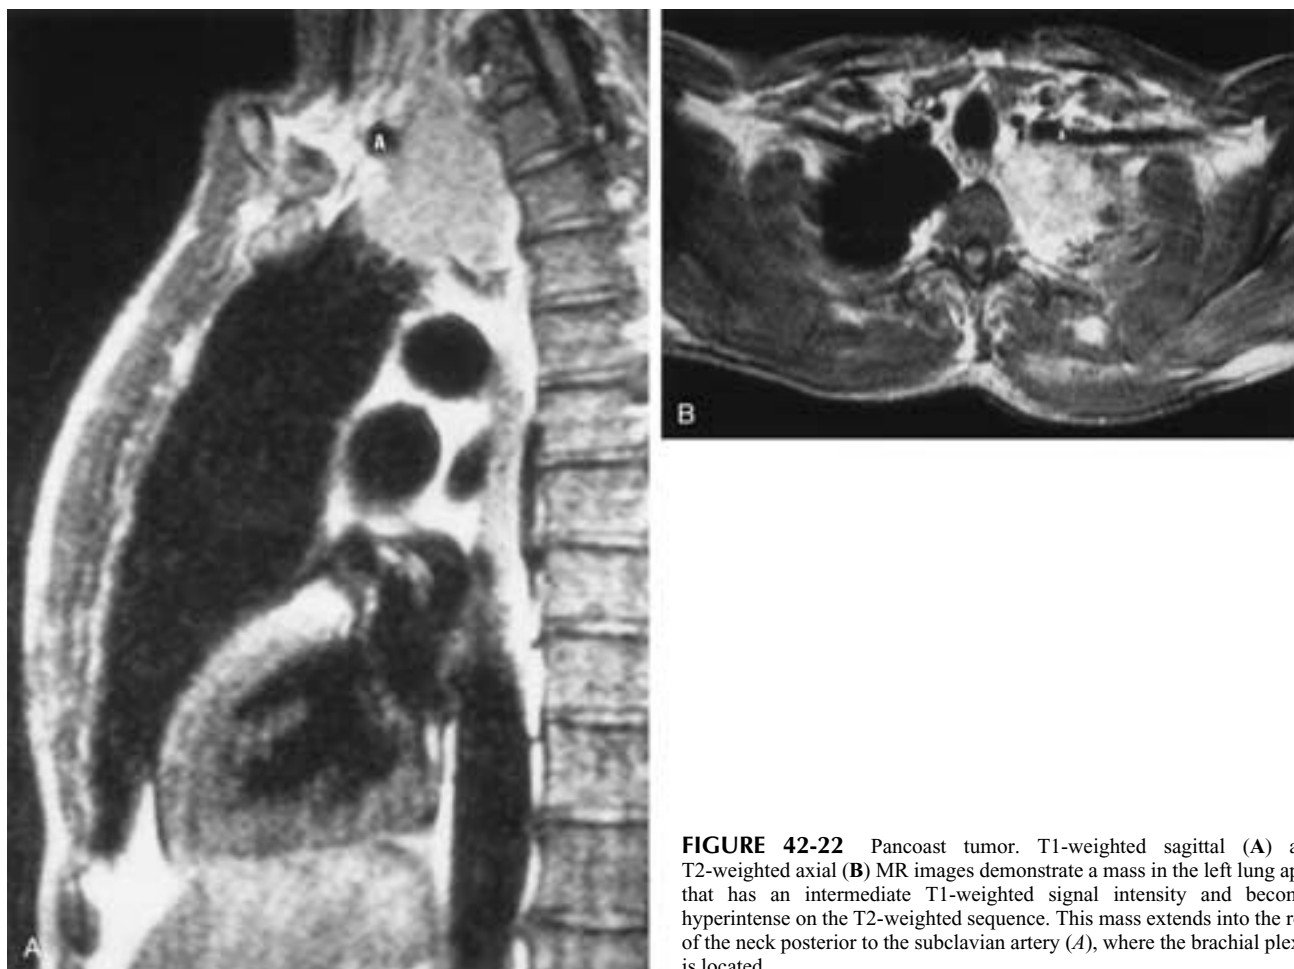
Pancoast tumor. T1-weighted sagittal (A) and T2-weighted axial (B) MR images demonstrate a mass in the left lung apex that has an intermediate T1-weighted signal intensity and becomes hyperintense on the T2-weighted sequence. This mass extends into the root of the neck posterior to the subclavian artery (A), where the brachial plexus is located.
